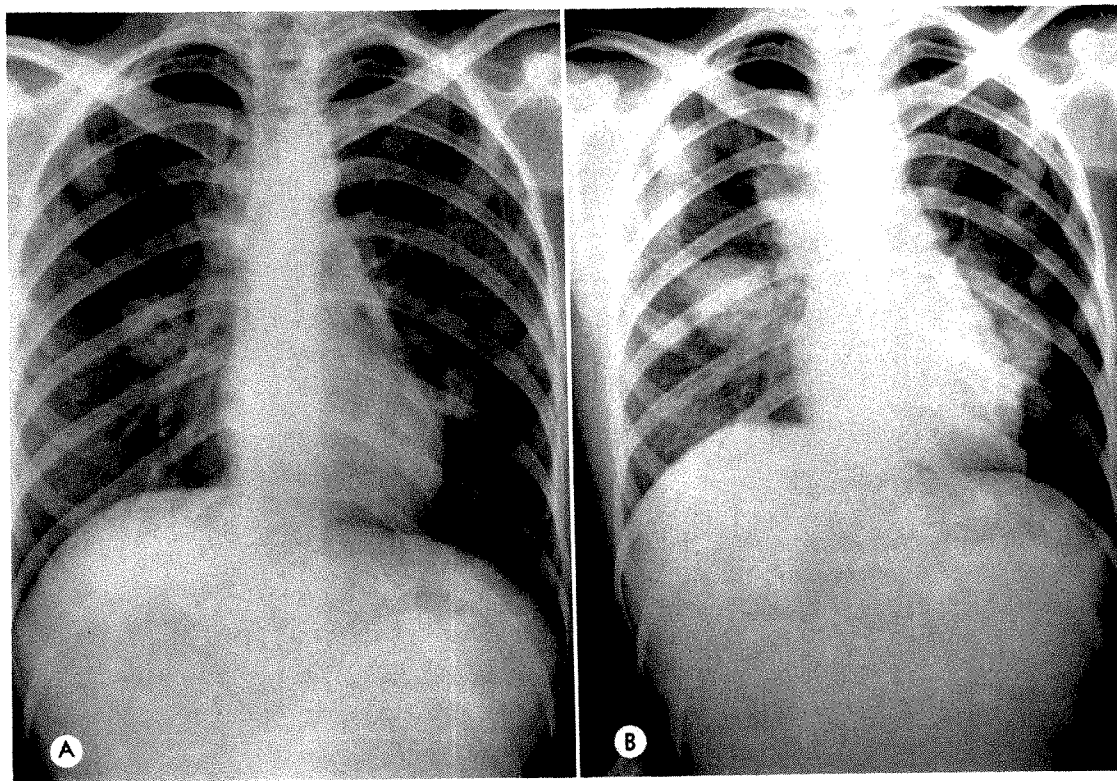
Multiple excavating pulmonary metastases in a twenty-six year old white female with disseminated medullary carcinoma of breast. (A and B) Cavitation of the type described by Wigh and Gilmore.³⁷ In the forty-four day interval between roentgenograms, the metastases have increased in size, but the cavities have disappeared or are partially filled, presumably as the result of bronchial obstruction.
